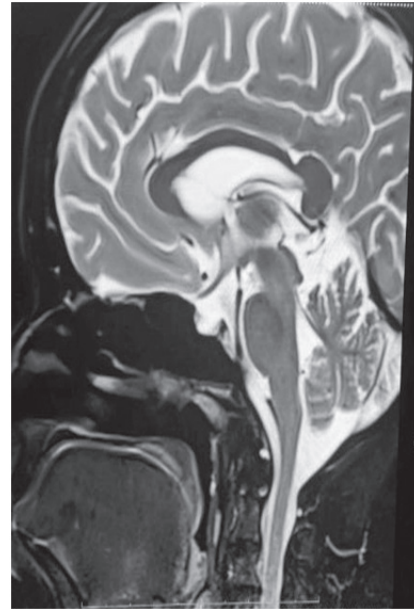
MRI brain T2-weighted sagittal image showing CSF-filled sella with flattened pituitary gland
